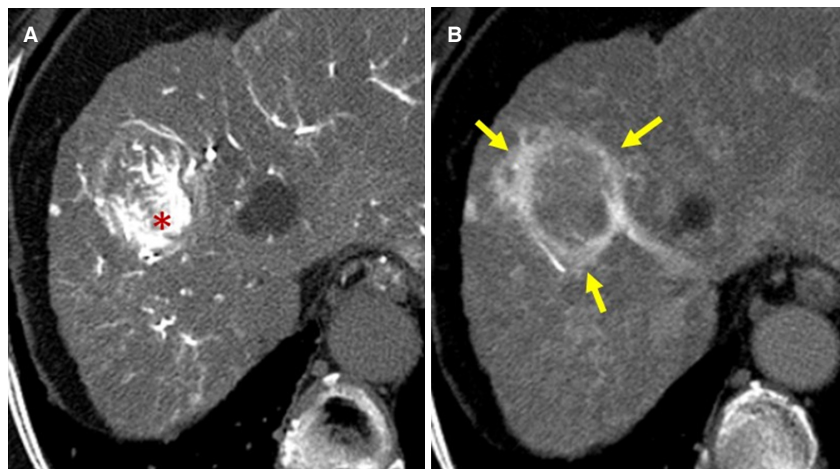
Example of corona enhancement caused by drainage flow from hypervascular HCC. A: on early phase image of CT during hepatic arteriography, HCC shows marked enhancement because of hypervascularity (*); B: on late phase image of CT during hepatic arteriography, since the intraarterial contrast injection is stopped, the enhancement of HCC decreases (*) and peritumoral normal liver parenchyma is enhanced by drainage of contrast material from HCC (arrow). HCC: hepatocellular carcinoma
